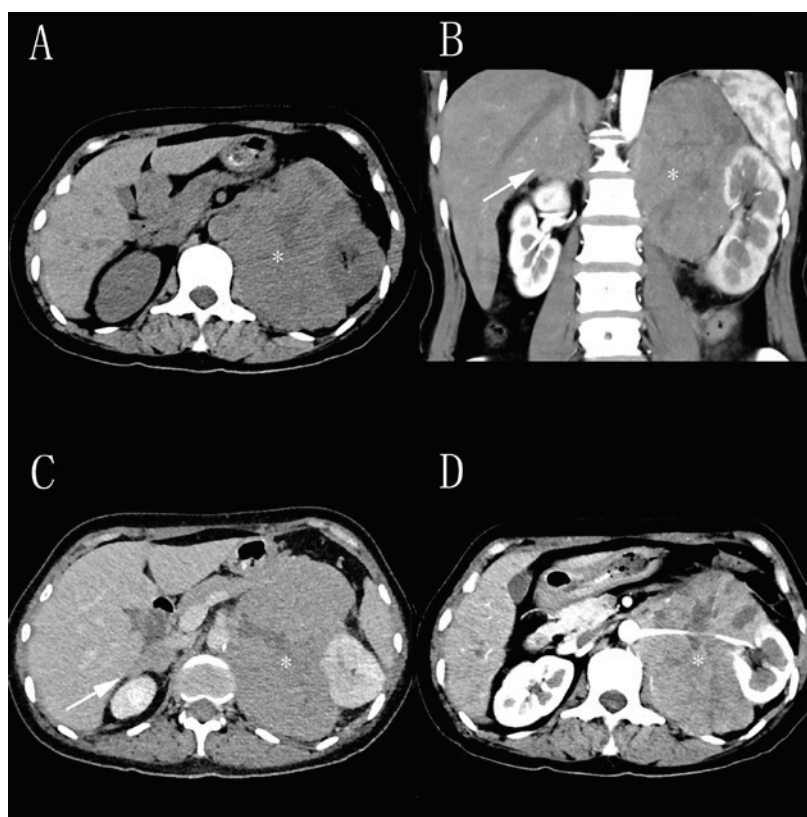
Computed tomography images of adrenal masses prior to (A) and following (B-D) intravenous administration of contrast material. It revealed a mass of 132x119x101 mm on the left adrenal gland (asterisk) and a mass of 53x27 mm on the right adrenal gland (arrow).
